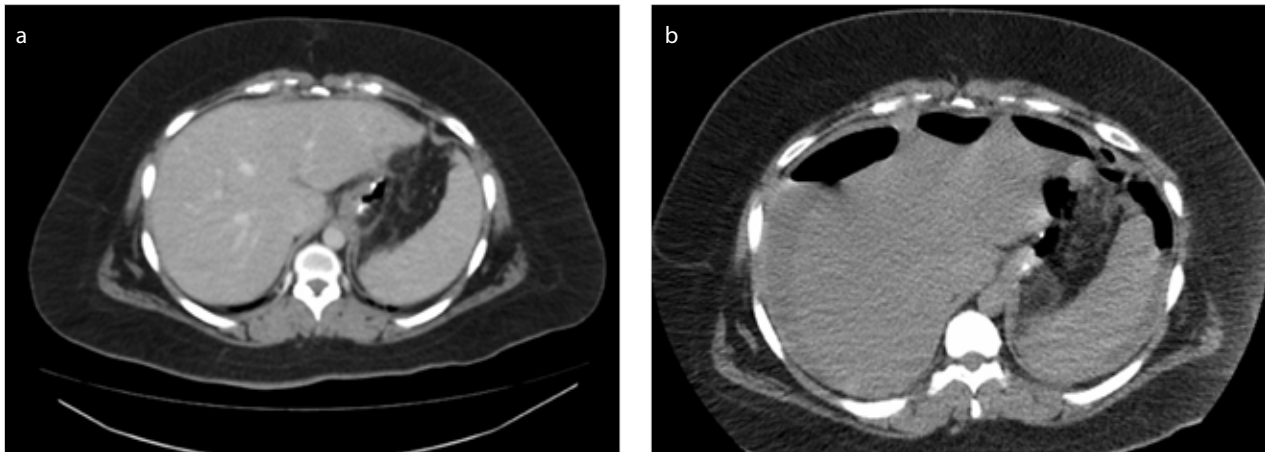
a, b. Initial CT scan showed normal findings (a), but 2 days later, the CT scan detected wide areas of free fluid in the abdomen (b)
